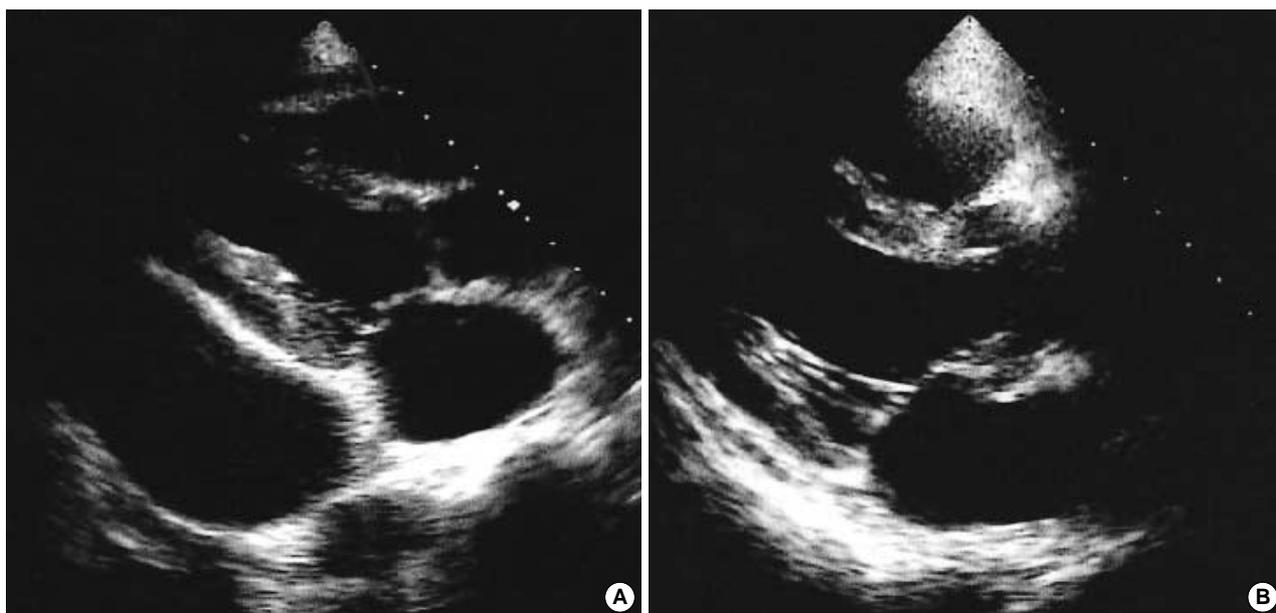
(A) Two-dimensional echocardiography on admission shows a large amount of pericardial effusion. (B) Follow-up echocardiography shows the nearly absorbed pericardial effusion and thickened pericardium.
